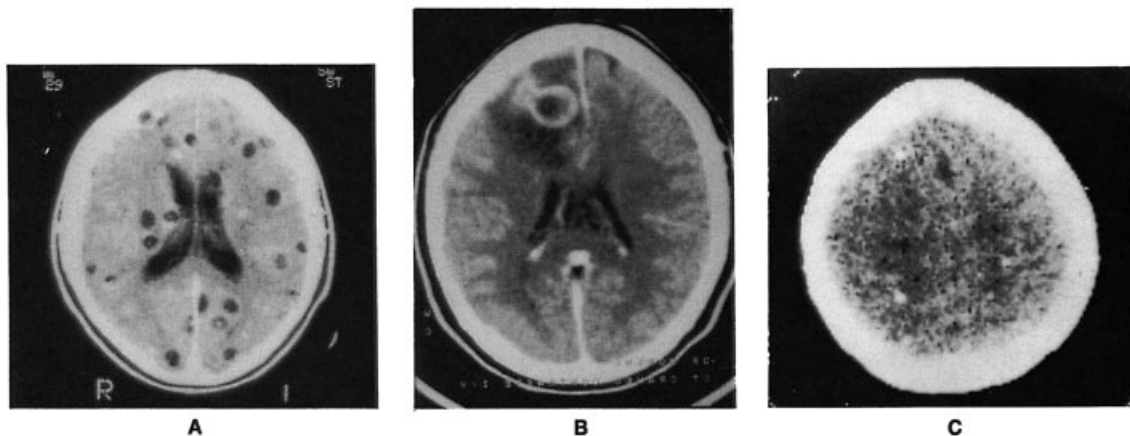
Computed tomographic findings in neurocysticercosis may be diverse according to the developmental phase of the parasite.^{23,24} (A) Multiple, viable intraparenchymatous cysts seen as rounded low-density areas. (B) Encephalitic-phase cysticercus in right frontal region presenting as a low-density area which, after contrast infusion, displays a nodular uptake. (C) Three calcifications of varying size are observed in both hemispheres
